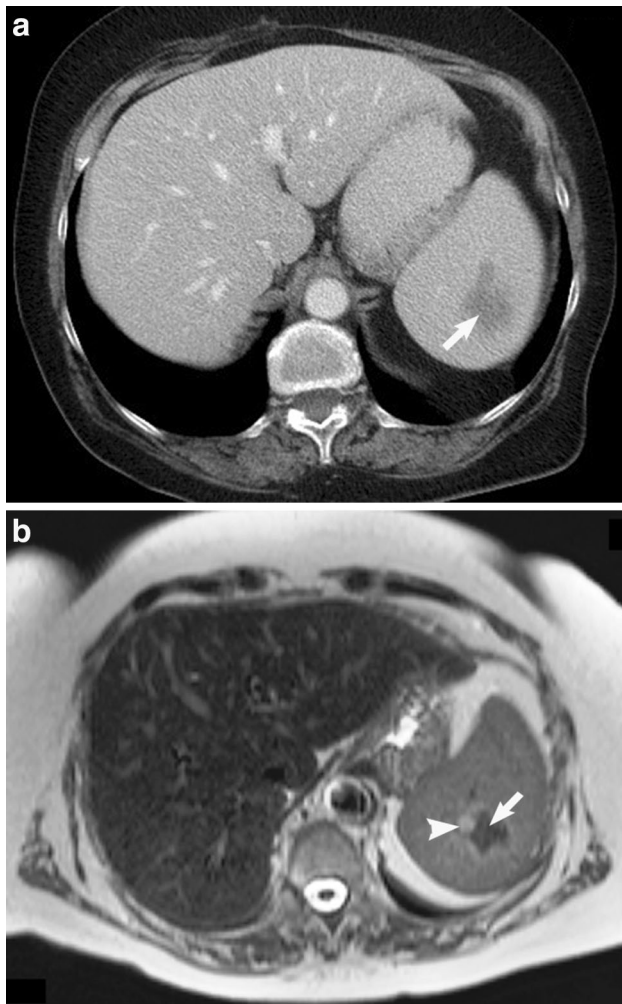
CT and MRI findings. a Abdominal CECT at the venous phase. Normal-sized spleen with a hypodense area (3×3.7 cm) (*arrow*) featuring irregular morphology and ill-defined borders located at the superior splenic pole (the lesion did not show any contrast enhancement in all CECT phases). b Abdominal T2-weighted images (WI) MRI. Normal-sized spleen with two adjacent splenic lesions: one (2.4 cm) (*arrow*) hypointense (as well as in T1-WI) and the other one (1.2 cm) (*arrow head*) hyperintense (vs isointense in T1-WI)
